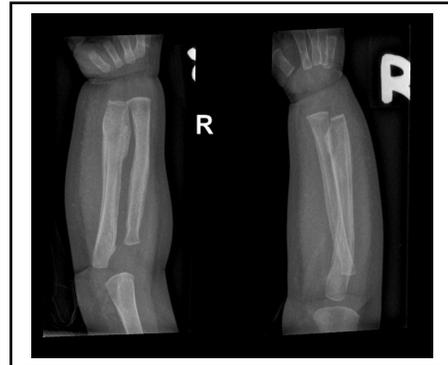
Radiograph of right radius ulna
